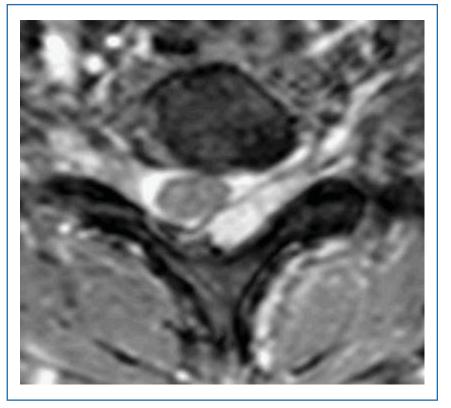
Cervical MRI, T2 axial view. Epidural hematoma C6-C7 compressing on left cord.
